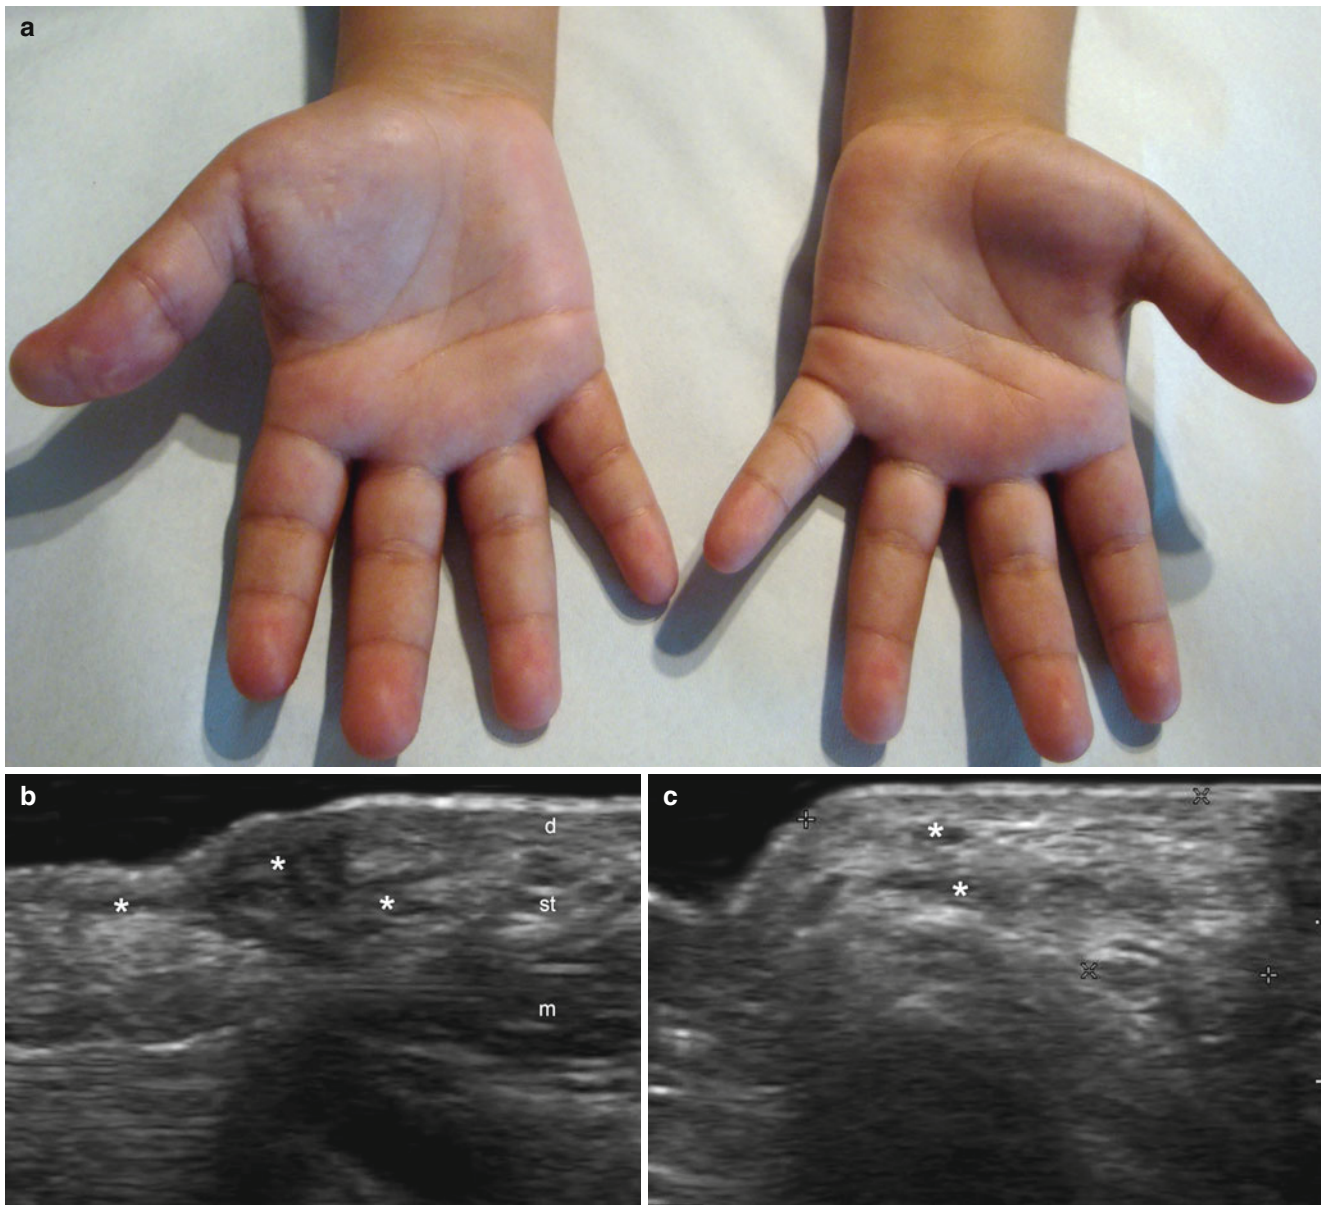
(a–c) Neural fibrolipomatosis. (a) Clinical image of a child presenting macroductyly in the right hand. (b) Ultrasound image (gray scale, longitudinal view at the thenar eminence) shows hypoechoic ill-defined pseudonodules and tracts (*) in the dermis and subcutaneous
